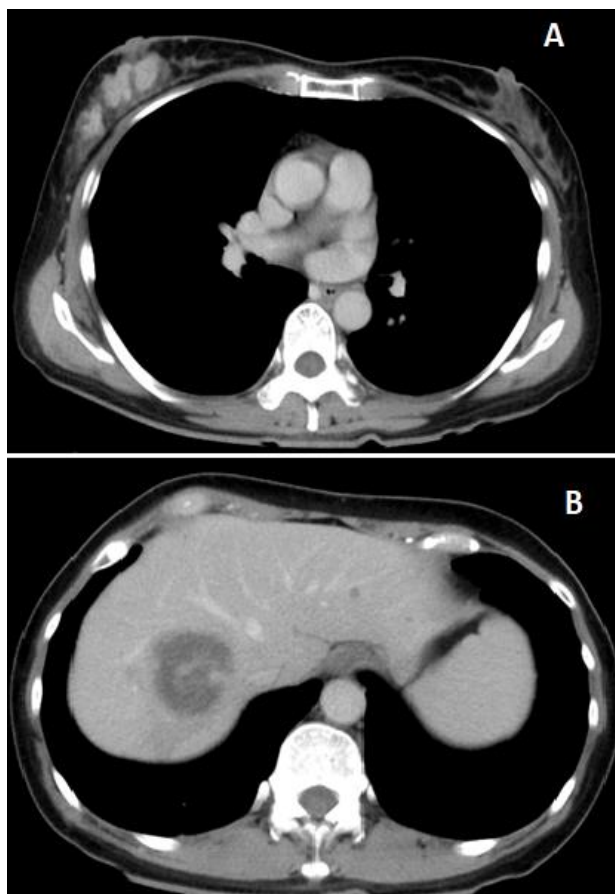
a. CT of primary tumor was performed at first; b. CT of liver metastases were performed at first.
